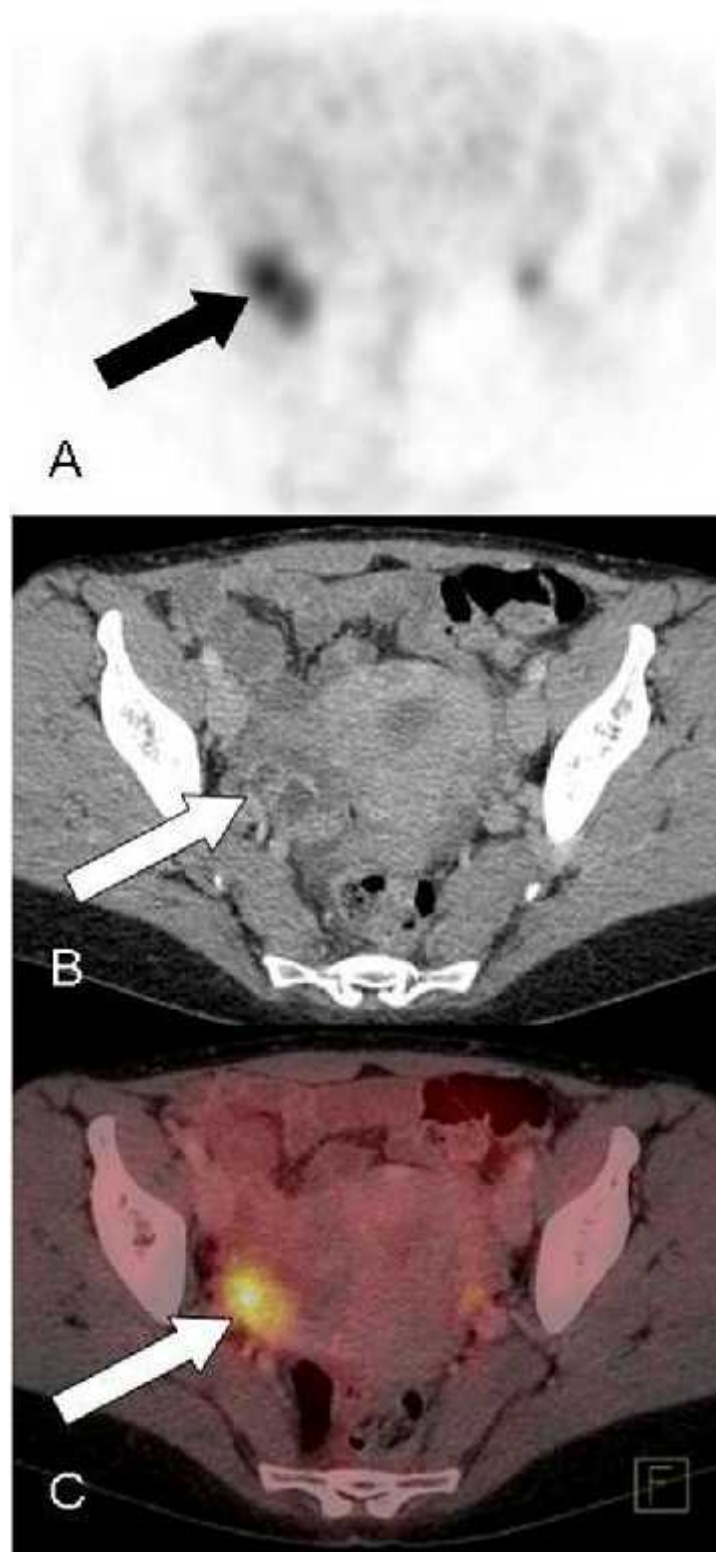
Transverse PET, intravenous contrast enhanced CT, and fused PET/CT images in a premenopausal woman with physiologic uptake in a normal ovary. A, There is a spherical area of increased FDG uptake (arrow) in the right adnexal region on PET. B, Morphologically normal right ovary (arrow) containing follicular and corpus luteum cysts as seen on CT. C, Fused images confirms increased FDG uptake is within the ovary (arrow)
